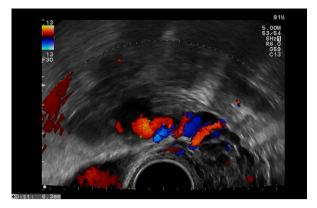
An example of tortuous veins visualized with pulsed Doppler during transvaginal ultrasonography, a possible sign of pelvic congestion syndrome. [Color figure can be viewed at wileyonlinelibrary.com].
